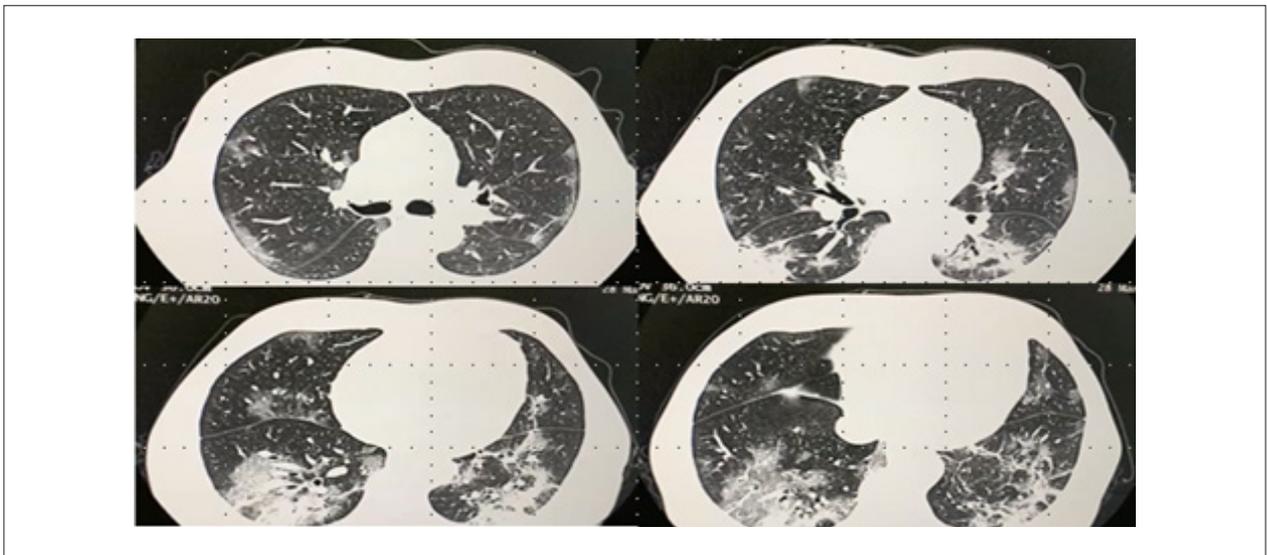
Chest computed tomography without contrast on hospital admission. Ground-glass opacities, mainly in peripheral areas and more evidently in lower segments, affecting less than 50% of the pulmonary parenchyma.
